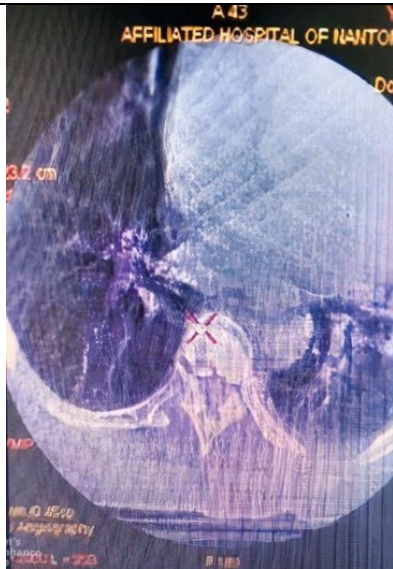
DSA type CT reconstruction immediately after operation shows that T7/8 central calcification has been cleared
